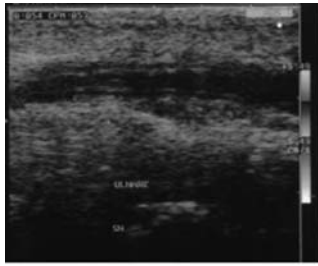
Ultrasound image of left ulnar artery showing arterial thrombosis and thickness with a triple ring aspect of the wall.
